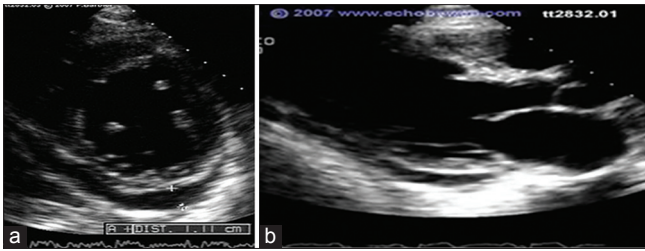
Echocardiographic picture of pericardial effusion, (a) parasternal short axis view, (b) parasternal long axis view
